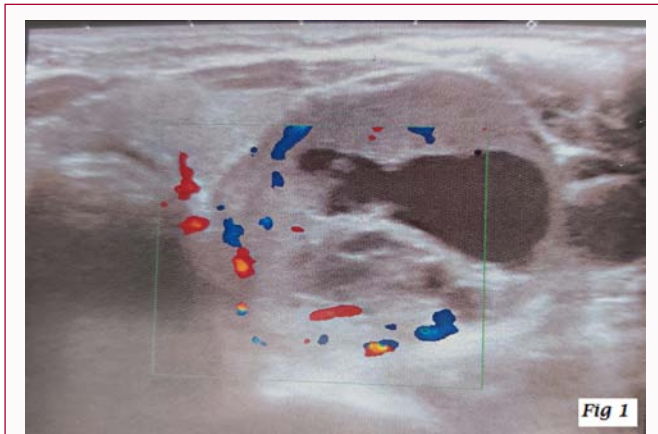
Ultrasonography showing a 3 cm mildly hypoechoic left thyroid nodule with an oval shape and regular margins, classified EU-TIRADS 4.
